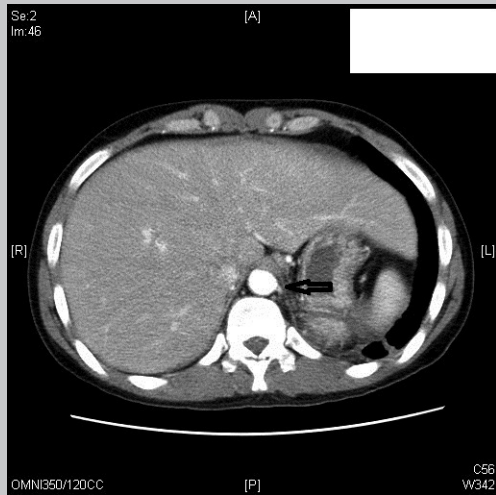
Computed tomography scan of chest and abdomen showing a small artery arising from abdominal aorta.
